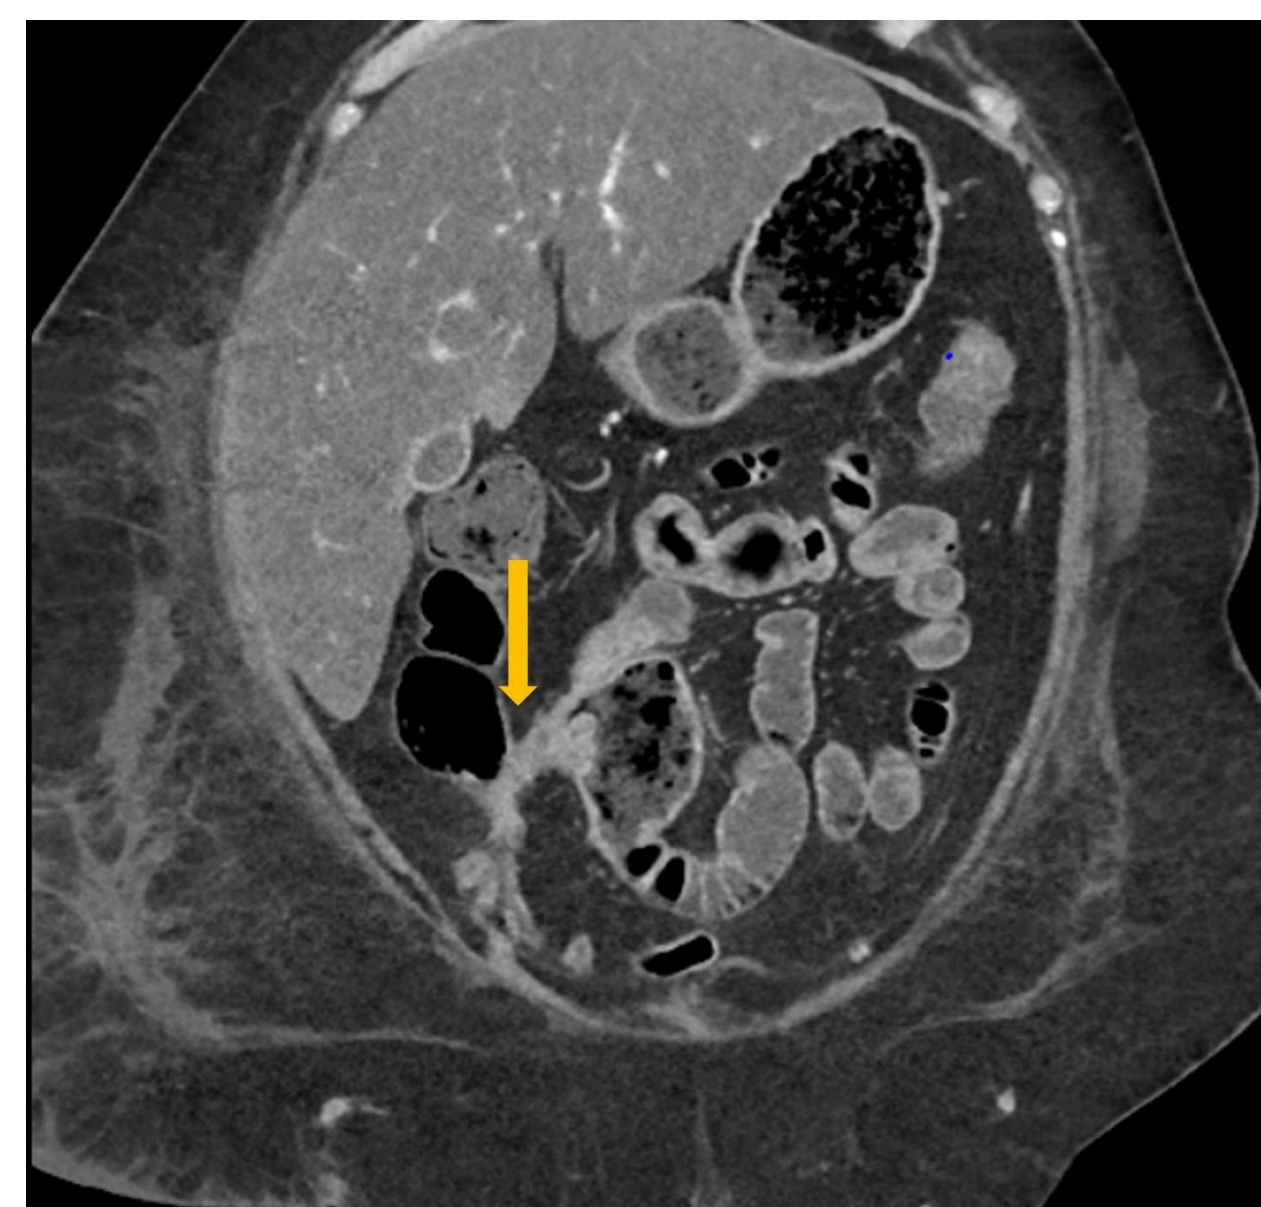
CT enterography demonstrating an entero-colic fistula.
